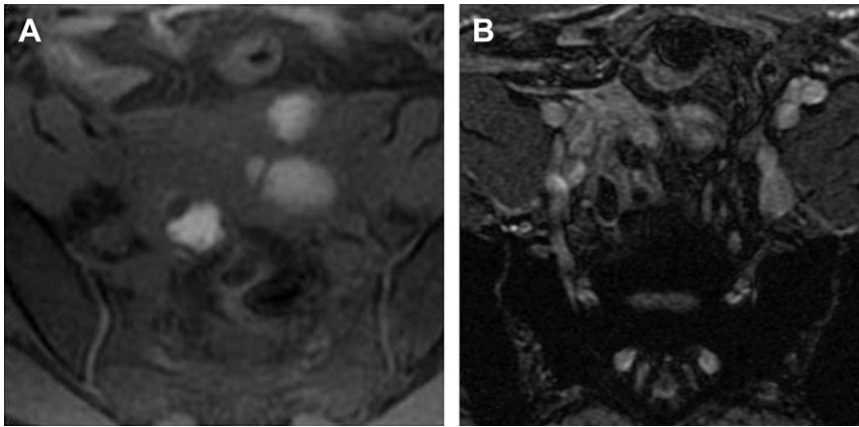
Endometrioma. Hyperintense cyst on axial T1-weighted image with fat suppression and signal voids along the cyst walls on the susceptibility-weighted image. (A) T1-weighted image. (B) Susceptibility-weighted image.
